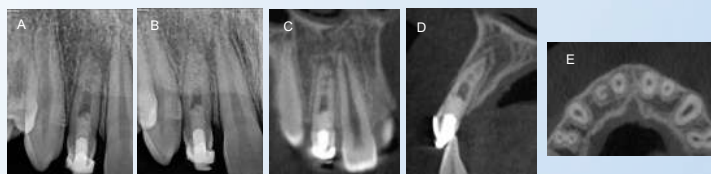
(A) Follow-up 6 month. (B) Follow-up 1 year. (C) CBCT coronal. (D) CBCT sagittal. (E) CBCT axial.
